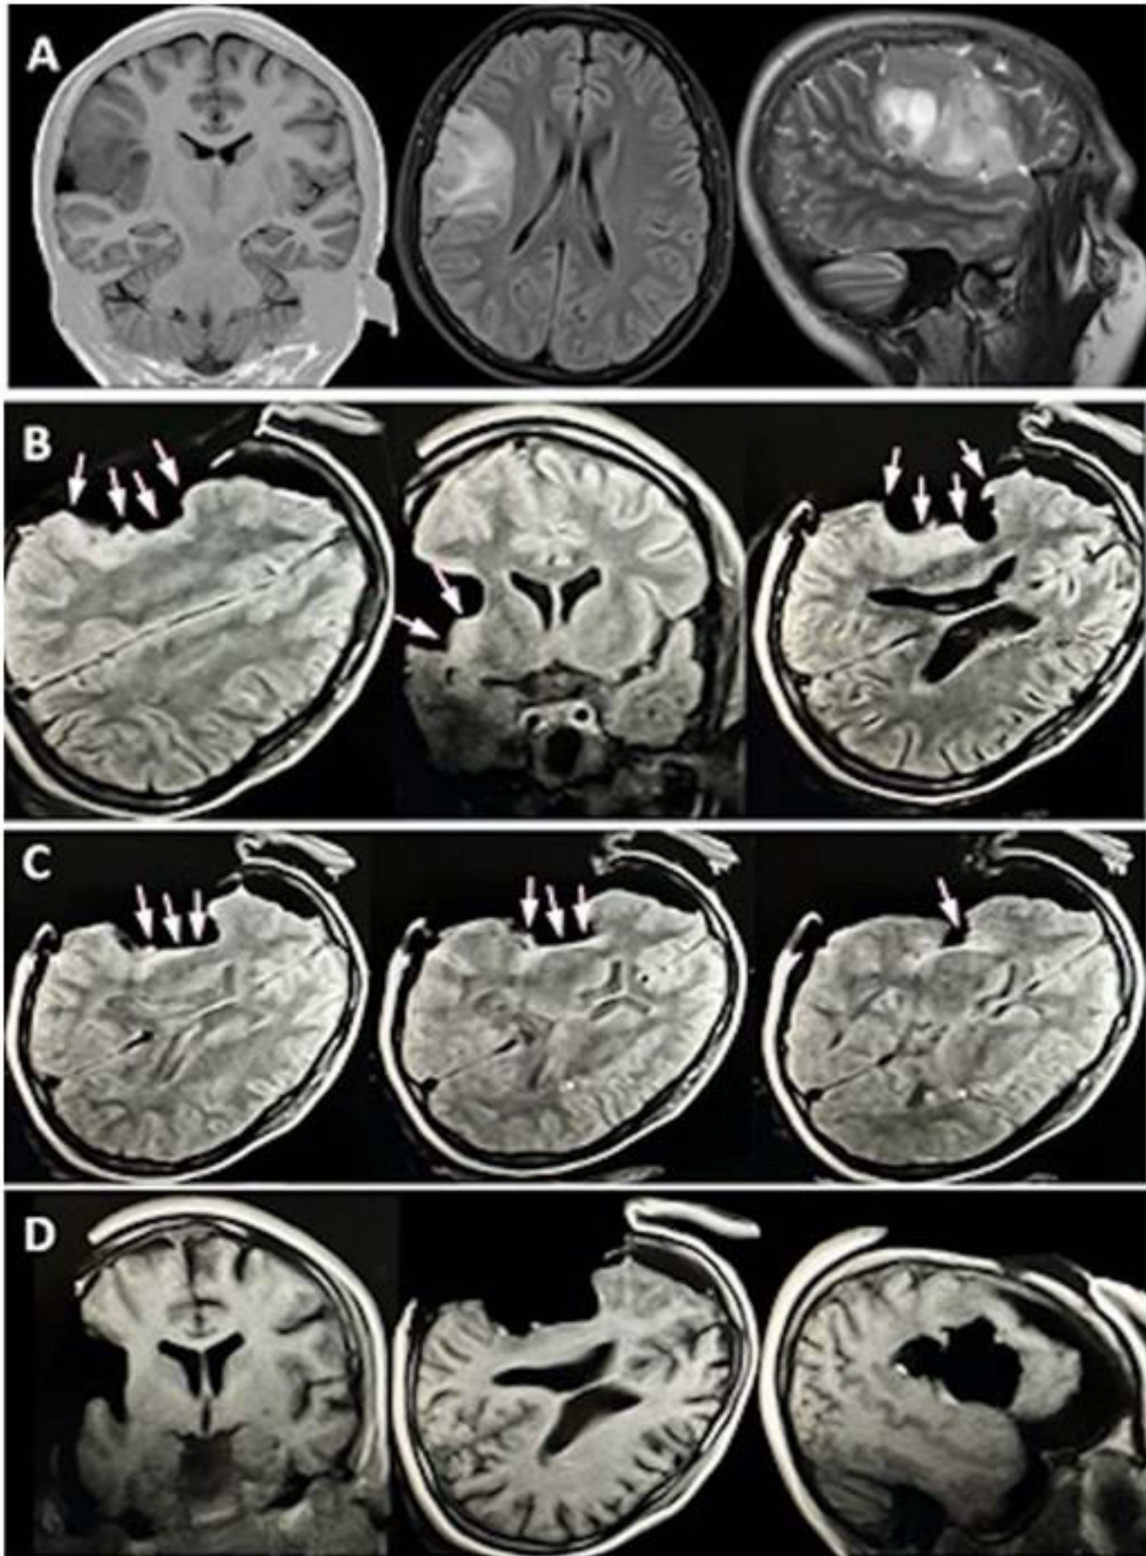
A: Preoperative 3-T MRI in high-grade glioma in right parietal-occipital region. B: Intrasurgery image with low-field MRI as surgical guided; a vitamin E capsule placed in a finger of sterile surgical glove is positioned into the surgical cavity to localize accurately the residual tumor in the operating field. C: Postsurgical 3-T MRI images, showing the gross total resection of brain glioma. D: "T" and pink line represents the presurgical location and volume of tumor.
